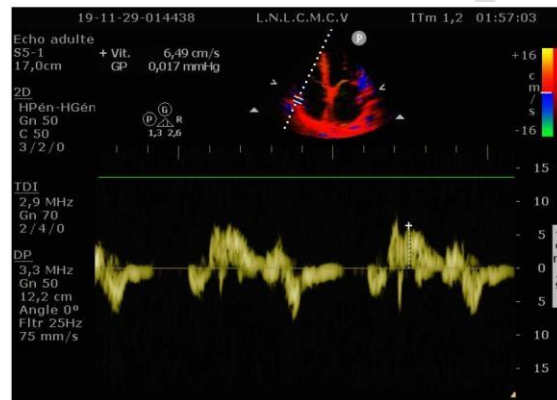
echocardiographic image showing tricuspid S wave alteration on tissue Doppler
